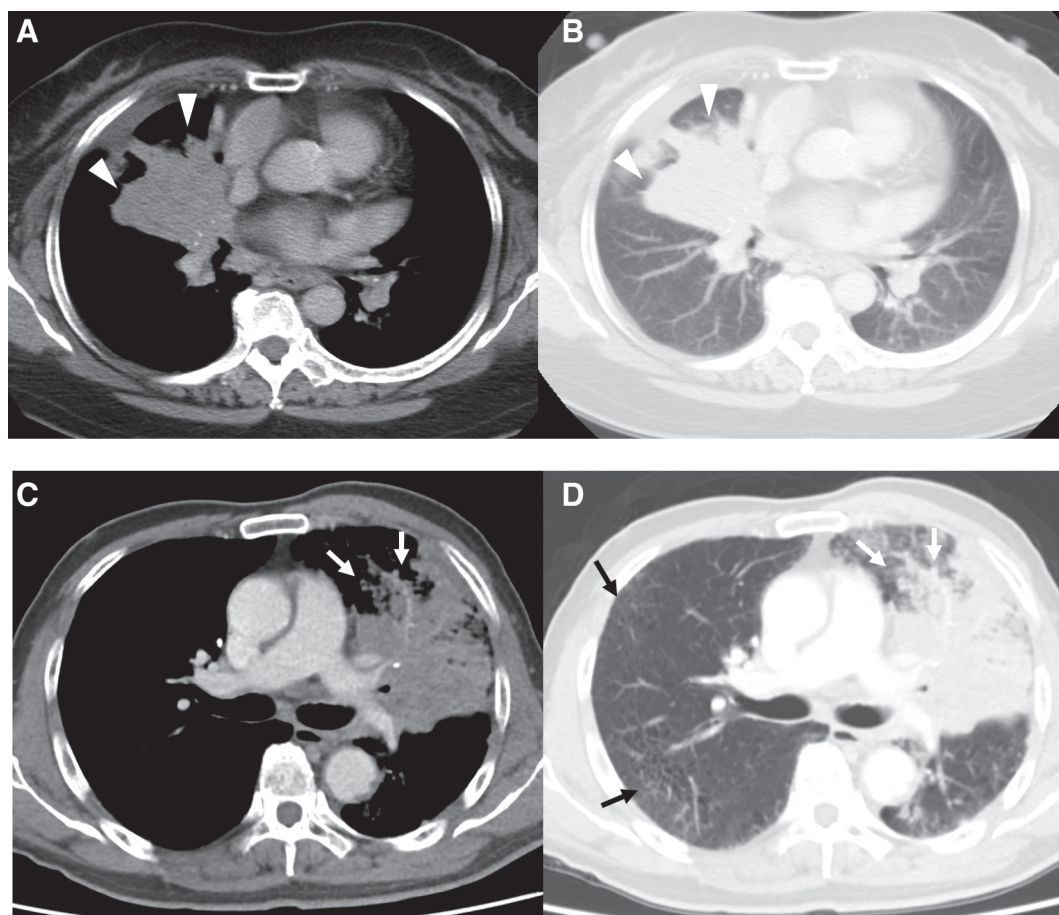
(A–D) A 58-year-old woman with stage 4 LELC. A CT scan with mediastinal window (A) and lung window (B) demonstrates a tumor situated in the RML. A 63-year-old man with stage 4 SCLC. A CT scan with mediastinal window (C) and lung window (D) demonstrates a tumor situated in the LUL. Both tumors are located centrally. However, the border of LELC is lobulated (white arrowhead) compared to the irregular border of SCLC (white arrows). The LELC shows more prominent enhancement (56 HU and 33% higher than right erector spinae muscles) compared to (C) SCLC (62 HU and 3% lower than right erector spinae muscles). Emphysematous change of the lung fields is conspicuous in the SCLC (black arrows). CT = computed tomography; LELC = lymphoepithelioma-like carcinoma; LUL = left upper lobe; RML = right middle lobe; SCLC = small-cell lung cancer.
